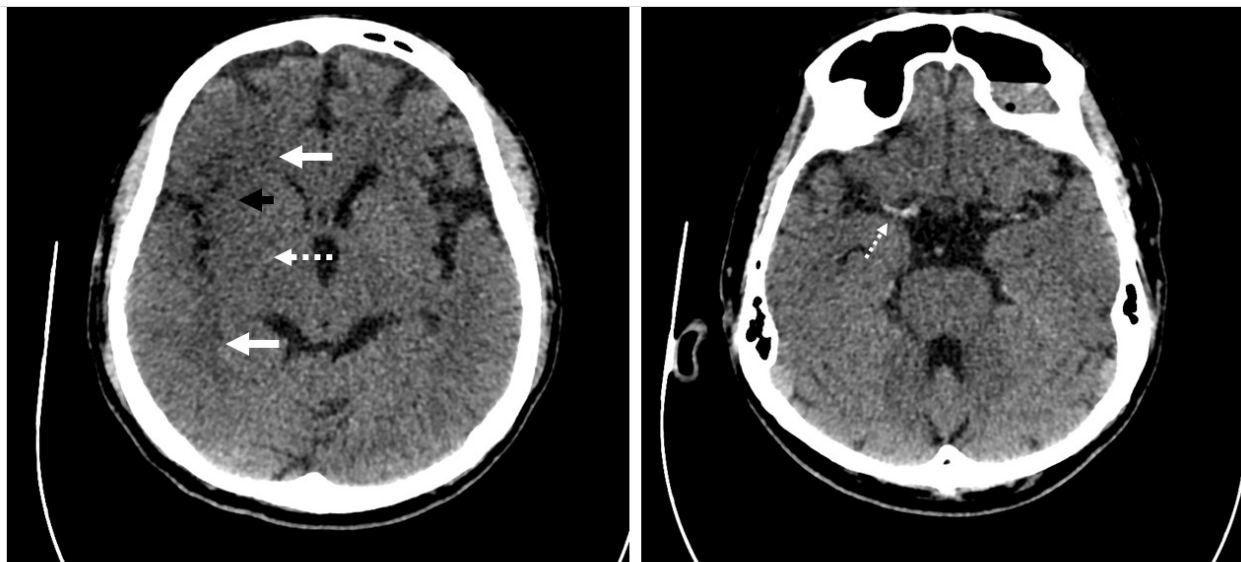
Head CT scan without contrast of patient in Case 3
